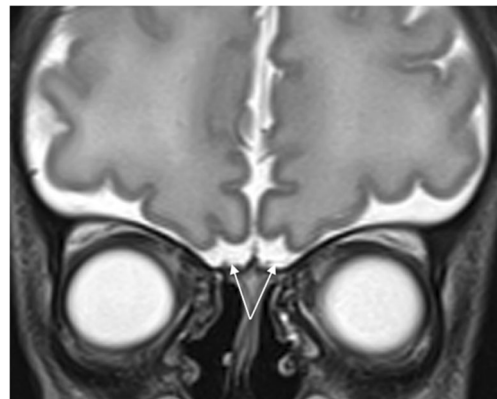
Case 3, an 8-day-old boy. T2-weighted coronal MR head image shows bilateral absence of the olfactory bulbs (*arrows*)
